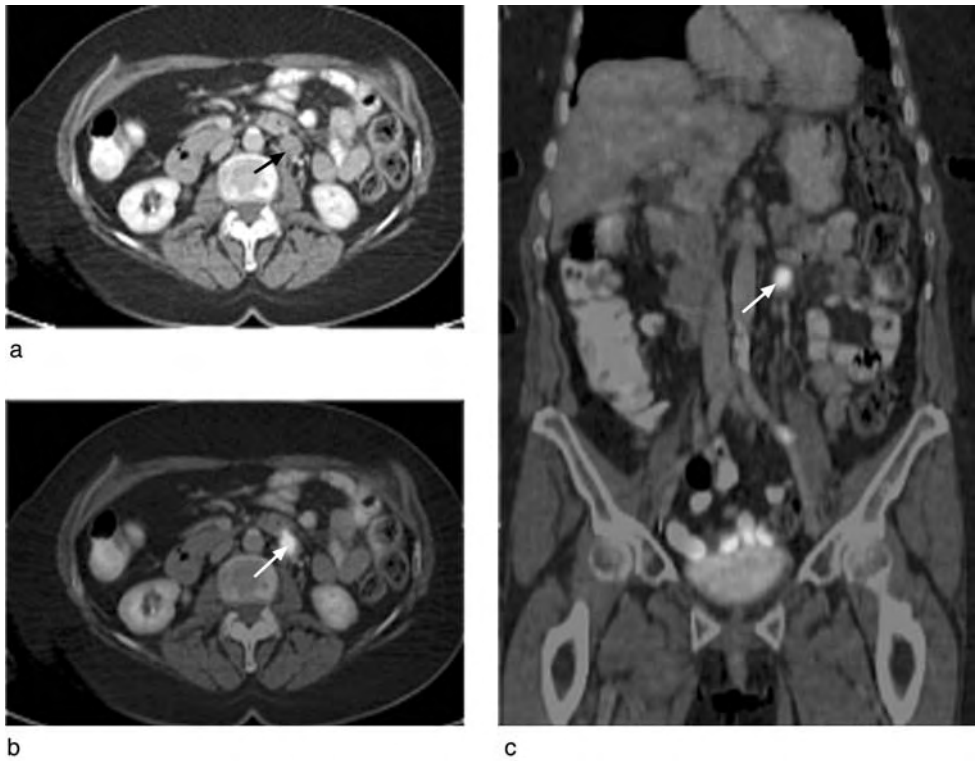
Patient with left para-aortic tumour recurrence. (a) The CT shows a small left para-aortic mass (arrowed). (b+c) Increased FDG uptake corresponding to a mass on CT (arrowed). (For a colour version of this figure please refer to colour plate section.)
